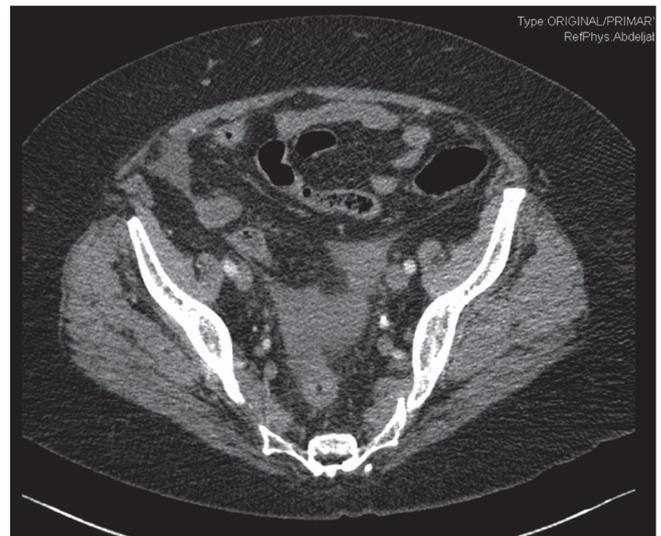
CT scan showing minimal amount of intraperitoneal free fluid as the only finding.
